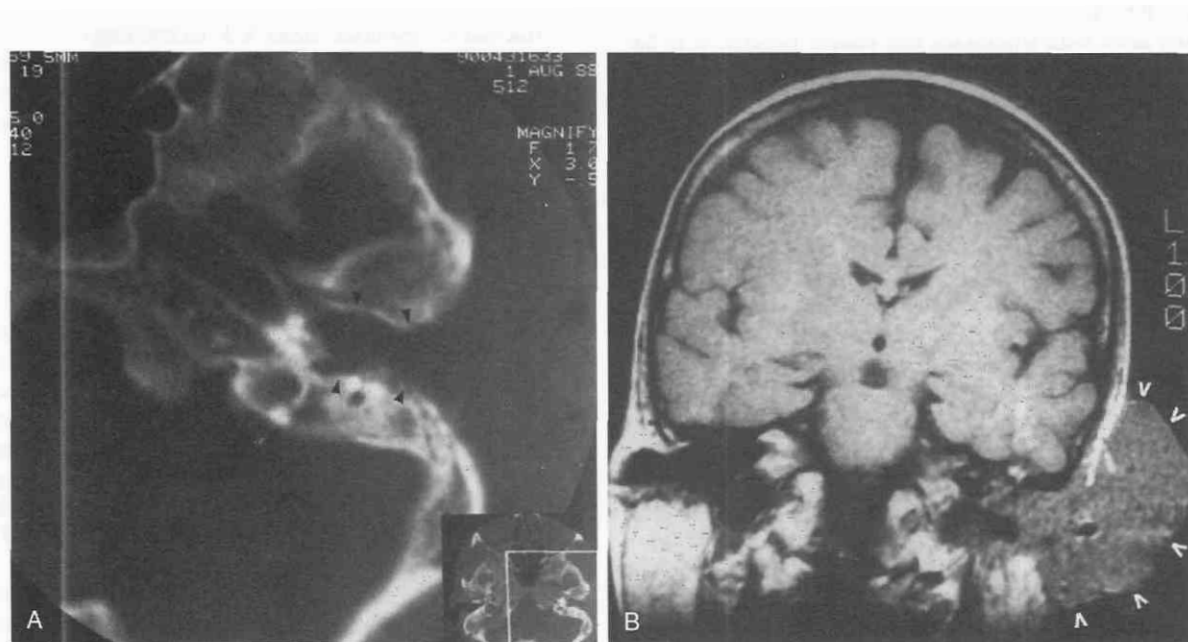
Basal cell carcinoma of the external auditory canal. A, Axial CT section through the left external auditory canal shows a soft tissue mass (black arrowheads) filling the canal and middle ear. Irregular destruction and expansion of the bony canal are shown. B, Coronal T1-weighted MRI study shows a large mushroom-shaped mass (white arrowheads) extending external from the auditory canal to involve the adjacent soft tissues. The normal fatty structures have been invaded.
